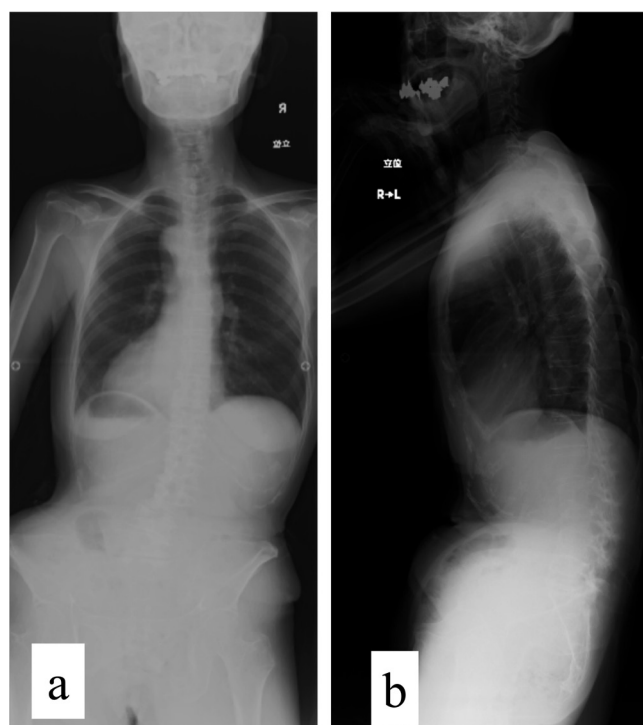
Preoperative whole-spine radiographs in the anteroposterior (a) and lateral views (b).
